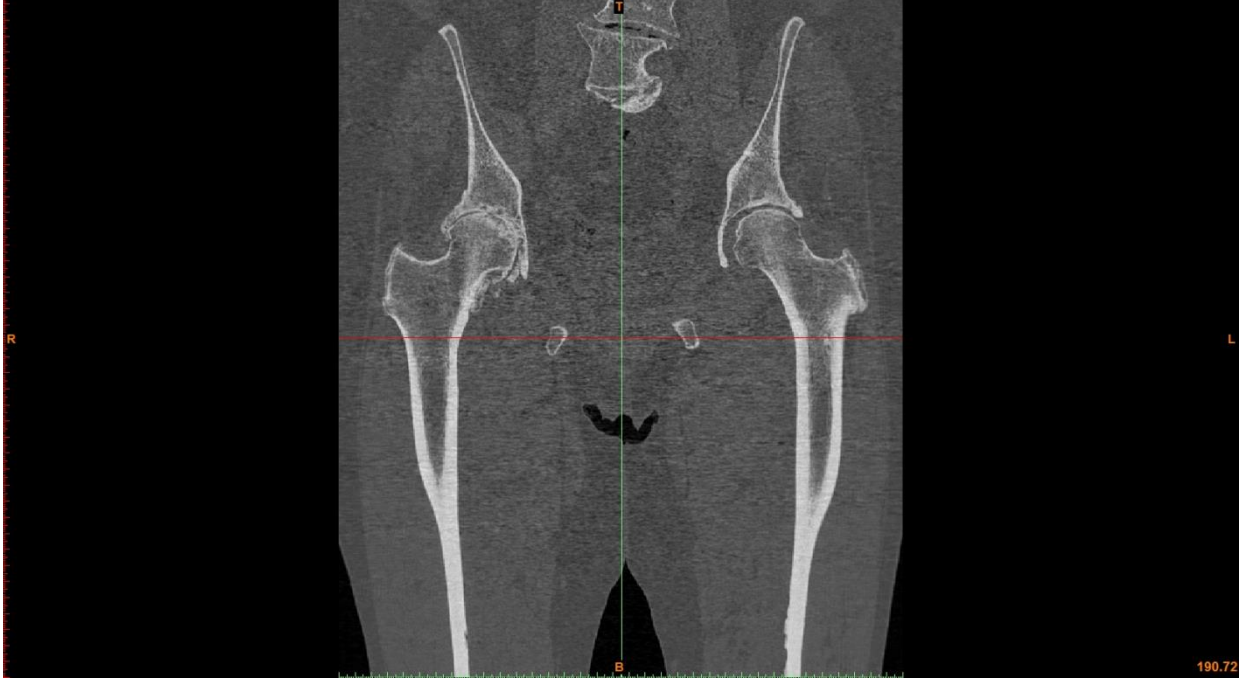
Coronal view of an CT image slice used in the study.
